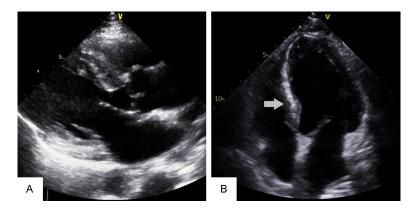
Transthoracic echocardiographic images in a patient with Fabry disease. A: Parasternal long-axis view showing concentric left ventricular hypertrophy. B: Apical four-chamber strain image demonstrating subendocardial brightness in the basal lateral wall. These findings are consistent with Fabry cardiomyopathy. The lesion is marked with an arrow.
